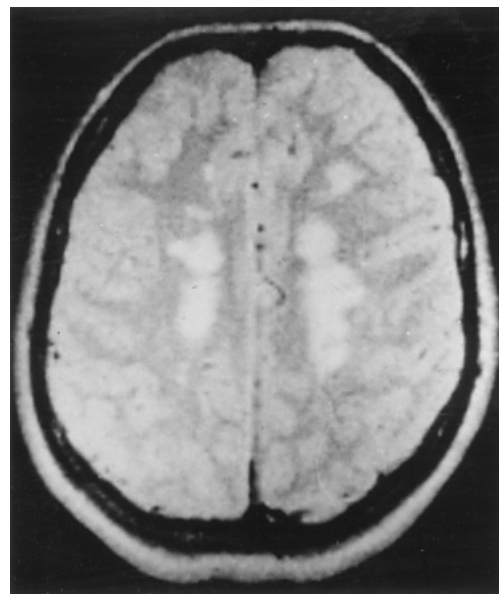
Proton-density weighted MRI of the cerebral hemispheres in multiple sclerosis. The white (high-signal) areas in both hemispheres represent the lesions of MS.
